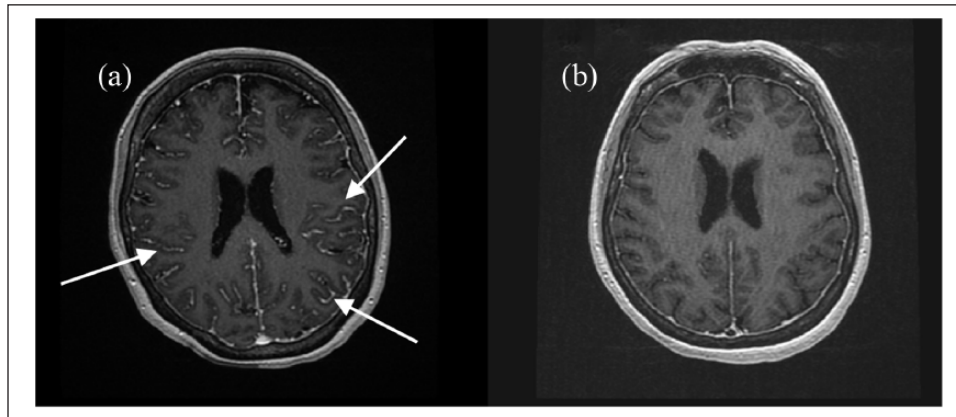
MRI, 3D axial T1 post contrast: (a) pre-steroid, diffuse leptomeningeal enhancement (white arrows); (b) post-steroids. Resolution of meningeal enhancement.
